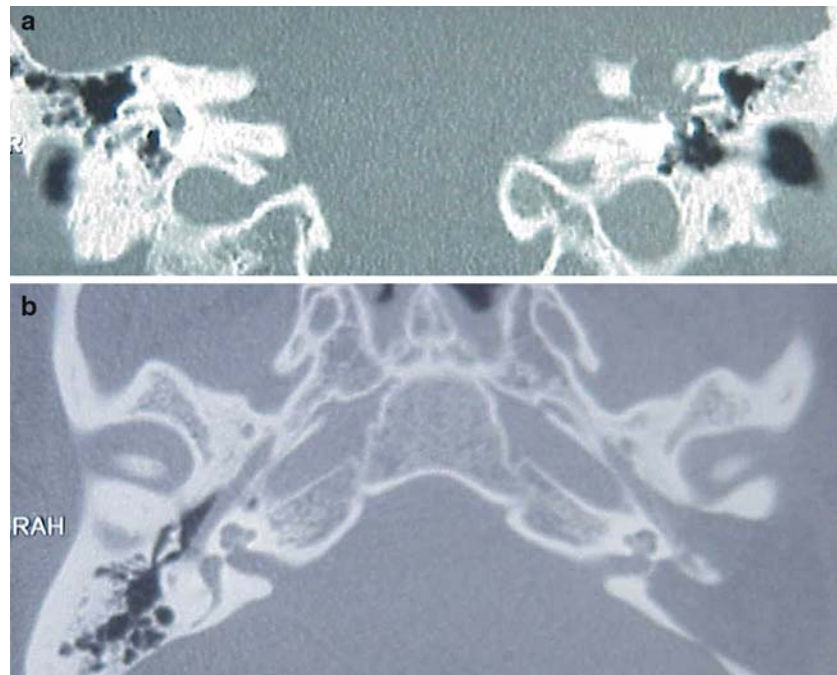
CT scan. Preoperative (a) massive petrous bone cholesteatoma. Postoperative (b) transcochlear approach
